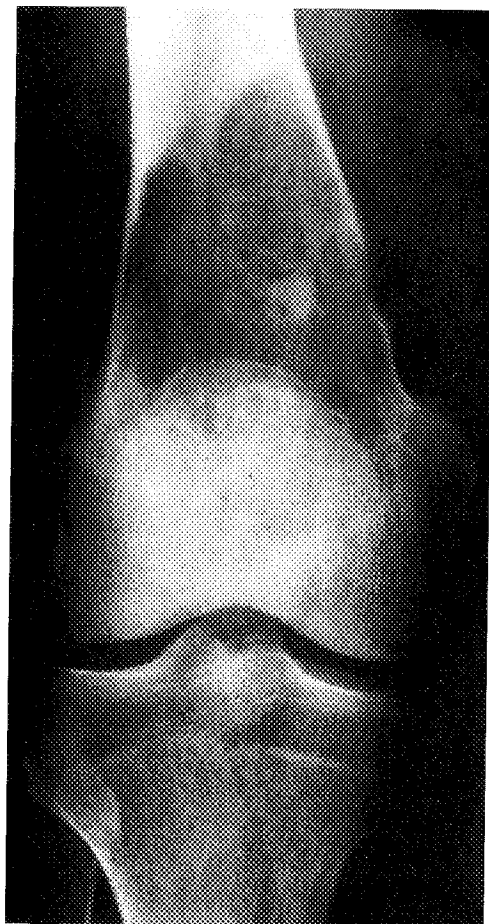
Anteroposterior view of a large LGIOS with cortical erosion and indistinct margins. Computed tomographic scan and magnetic resonance imaging showed the permeating margins and cortical bone erosion. The lesion extended to the metaphysis and epiphysis of the distal femur. All mounts confirmed the radiologic staging study (Patient 2).
